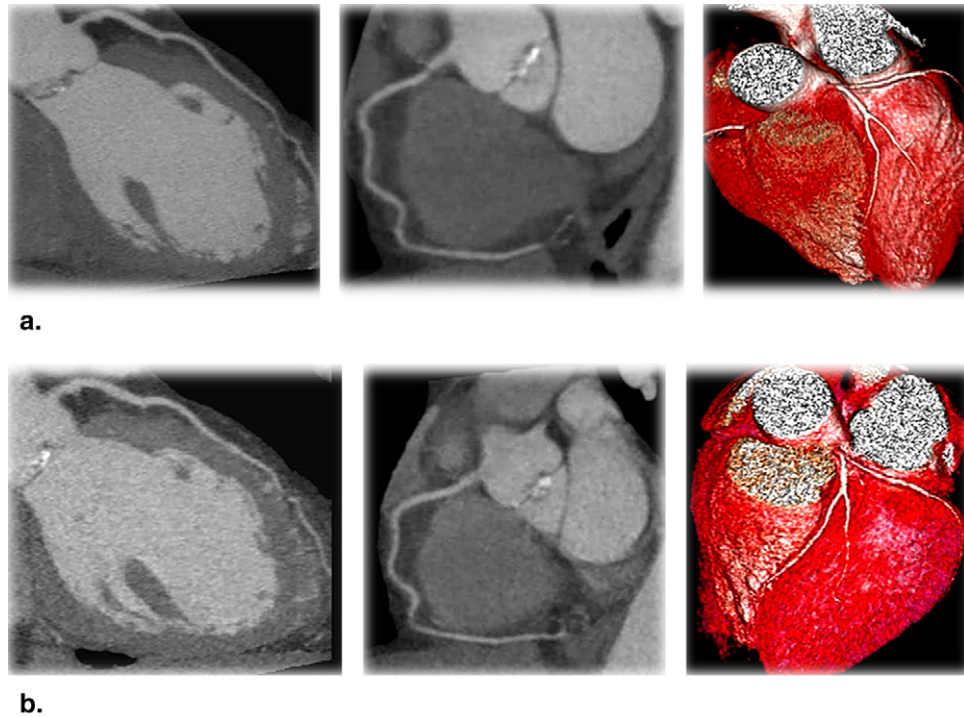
A 320-detector coronary computed tomography angiography in a 37-year-old woman with nonspecific chest pain and dyspnea. Heart rate 63 beats/minute, body mass index 27. Extensive calcifications in aortic valve leaf are seen. (a) Standard protocol (4.1 mSv), (b) low-dose protocol (0.88 mSv).
